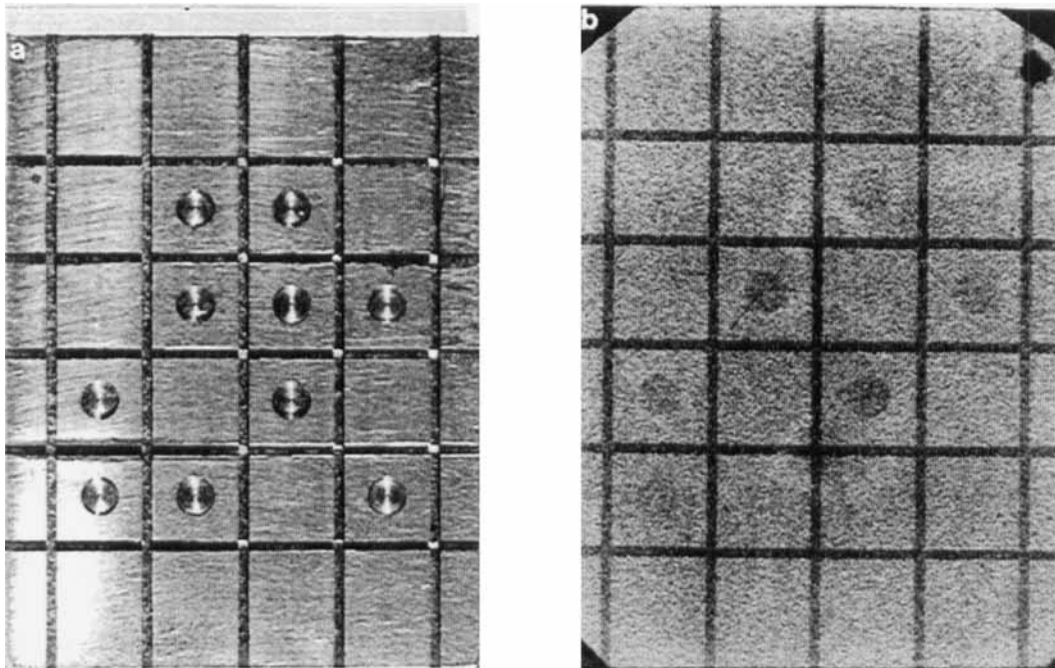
Test object (a) and radiograph of the test object (b).
